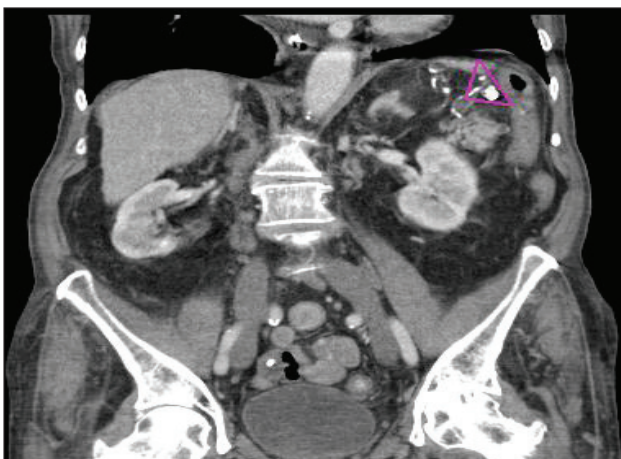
Coronal section of the abdominal computed tomography scan showing the hypoplastic and calcified spleen
